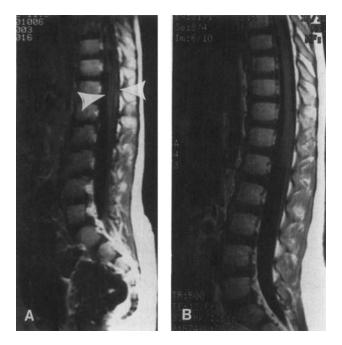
A: Post-contrast sagittal T1-weighted image of the lumbar spine performed on patient in Case 3 in March 1993, immediately prior to commencement of cyclophosphamide therapy, shows abnormal enhancement around the conus medullaris representing metastatic disease (arrowheads). B: The same patient's study performed in November 1993, 4 months following completion of chemotherapy, shows total resolution of tumor. No abnormal enhancement is identified.
